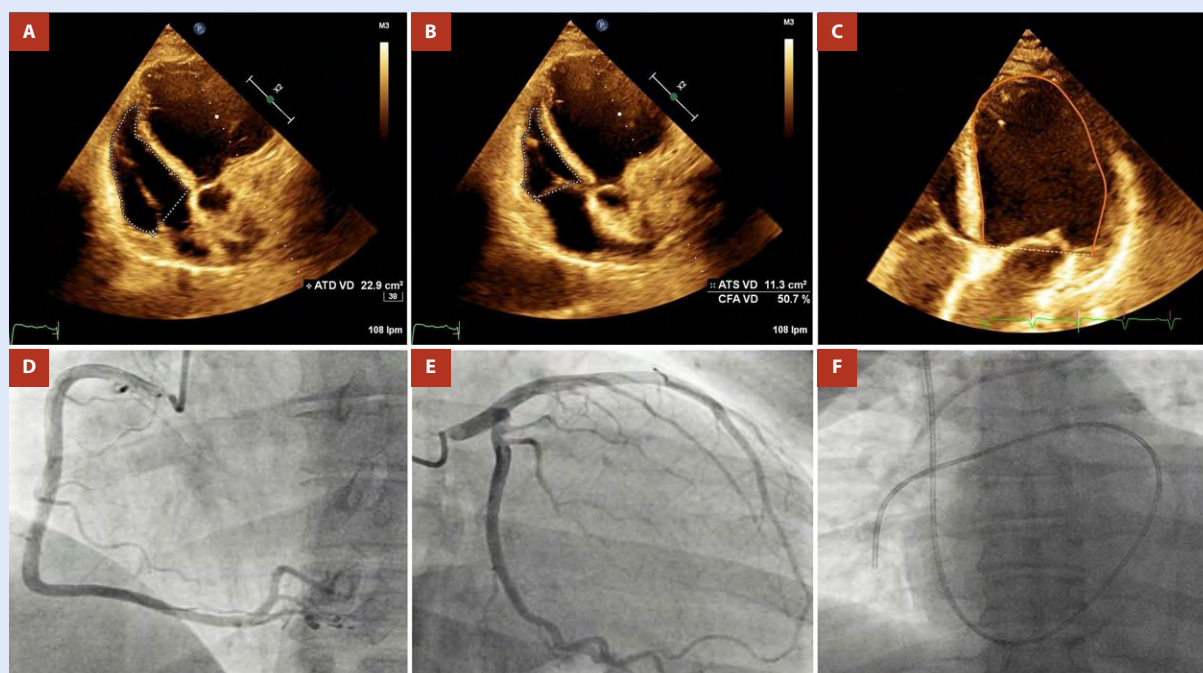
Follow-up multimodality imaging after anticoagulation and hemodynamic stabilization. A. Follow-up transthoracic echocardiography (apical four-chamber view) performed 10 days after initiation of full anticoagulation demonstrates complete resolution of the previously visualized RV thrombus. B. Apical four-chamber view showing significant improvement in RV FAC of 50.7%, compared with severely depressed function at baseline. C. Left ventricular-focused apical four-chamber view used to calculate left ventricular ejection fraction, which was 27%. D–E. Invasive coronary angiography demonstrating angiographically normal coronary arteries in both right and left coronary systems, effectively excluding obstructive epicardial coronary disease as a contributor to the ventricular dysfunction. F. Posteroanterior fluoroscopic projection demonstrating a Swan–Ganz catheter in appropriate position for right-heart hemodynamic assessment.
